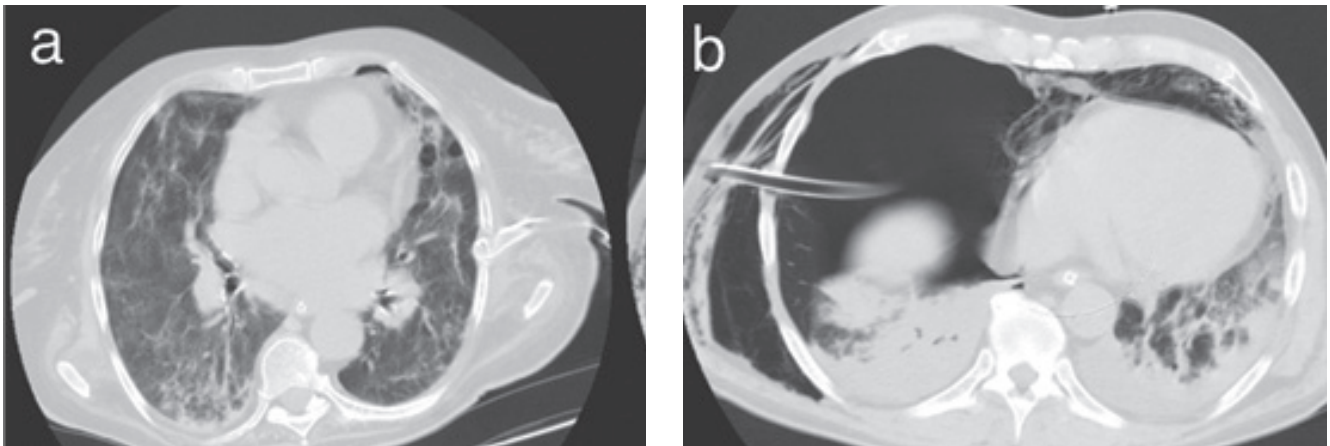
CT imaging in COVID-19 patients: a) expanded lung after left minimal pleurotomy; b) unexpanded lung after right minimal pleurotomy.
